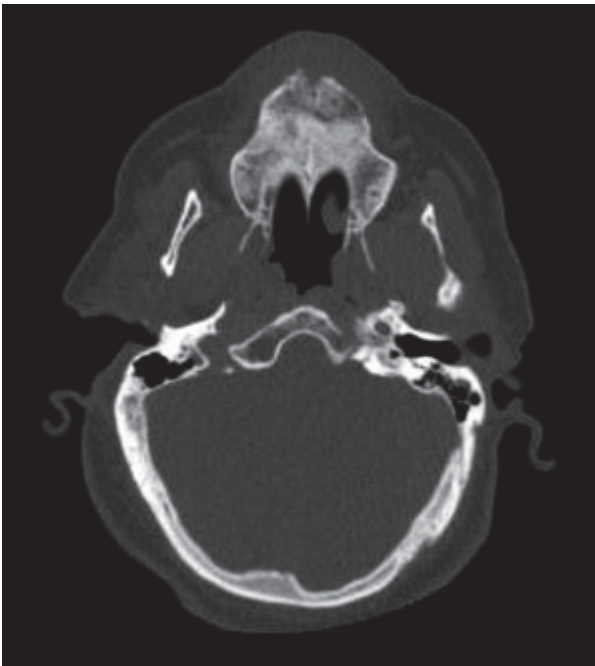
Computed tomography (CT) examination revealed osteonecrosis in the premaxillary region, with an ill-define
